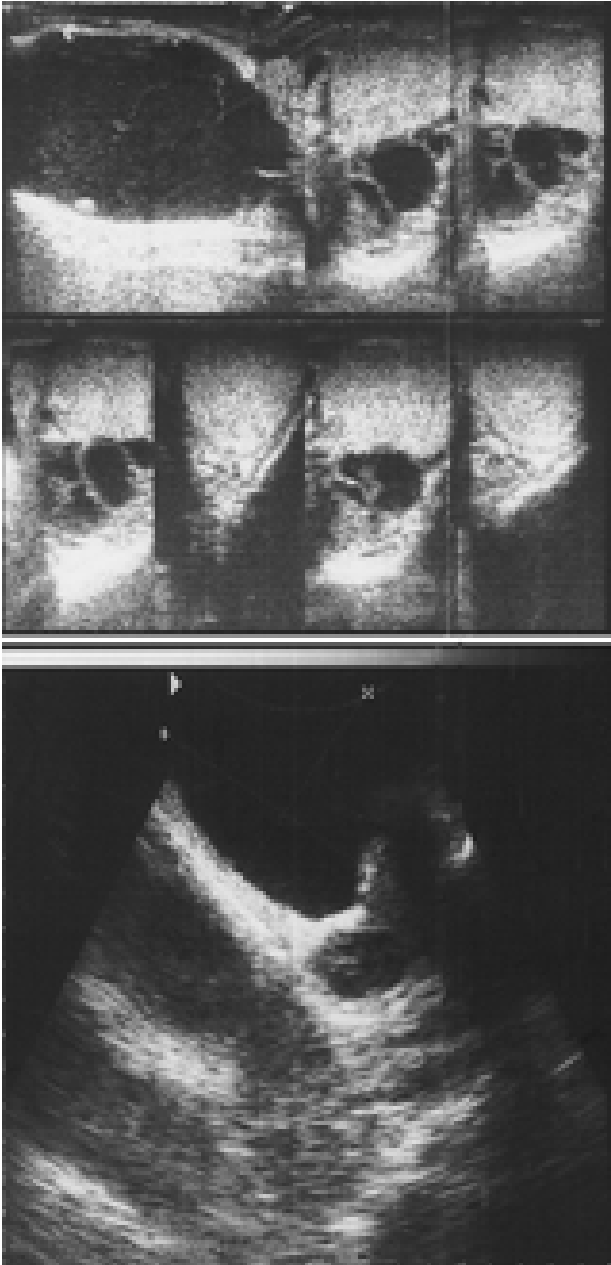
Two multicystic lesions in the right scrotum on sonography
